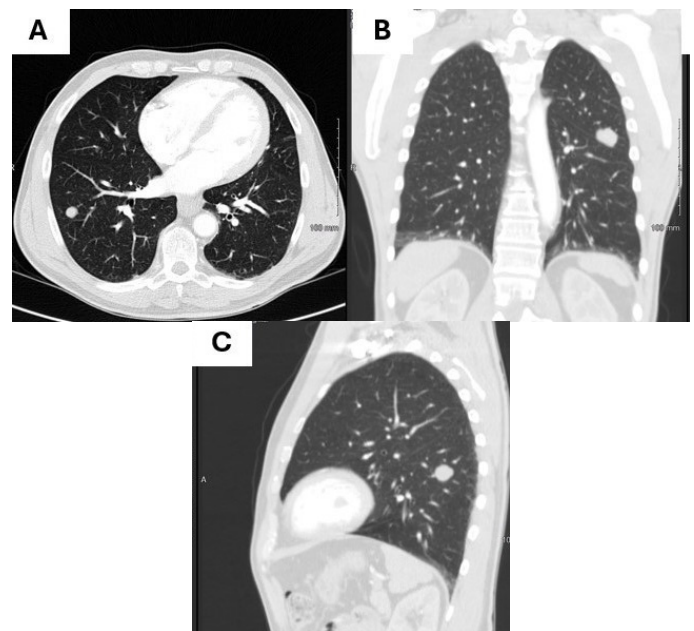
Metastatic melanoma presenting as multiple bilateral noncalcified pulmonary nodules on non-contrast CT imaging. (A) axial view; 4mm pulmonary nodule in right middle lobe. (B) coronal view; pulmonary nodule (25mm x 19mm) in left upper lobe. (C). sagittal view; 11mm pulmonary nodule in left lower lobe.
